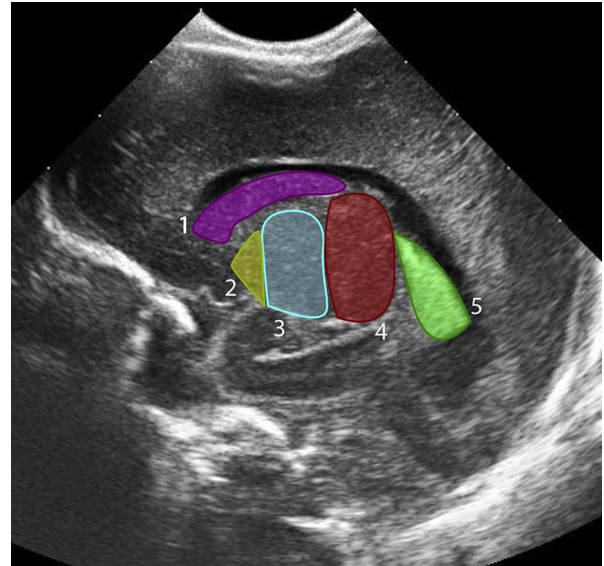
Parasagittal ultrasound image through the anterior fontanel. This image gives a good overview of the structures of interest and the various nuclei are easily recognized. Structures: 1. Caudate nucleus; 2. Putamen; 3. Globus pallidus; 4. Thalamus; 5. Choroid plexus.
